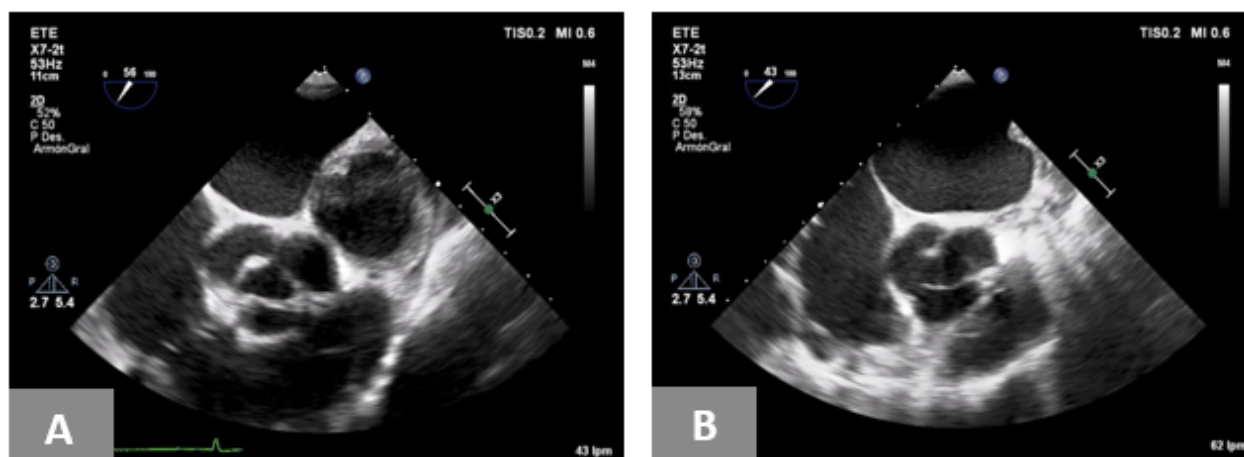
Transesophageal echocardiogram in high esophageal plane at 43-56°: A. Giant pseudoaneurysm B. It shows the absence of the pseudoaneurysm with postresection cicatricial changes.
